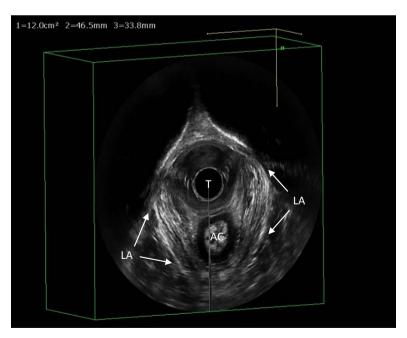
Three-dimensional transvaginal ultrasound image obtained with a 360° rotational transducer. The levator ani (LA) muscle is visualized as a multilayer structure coursing lateral to the vagina and posterior to the anal canal (AC). T: transducer.
